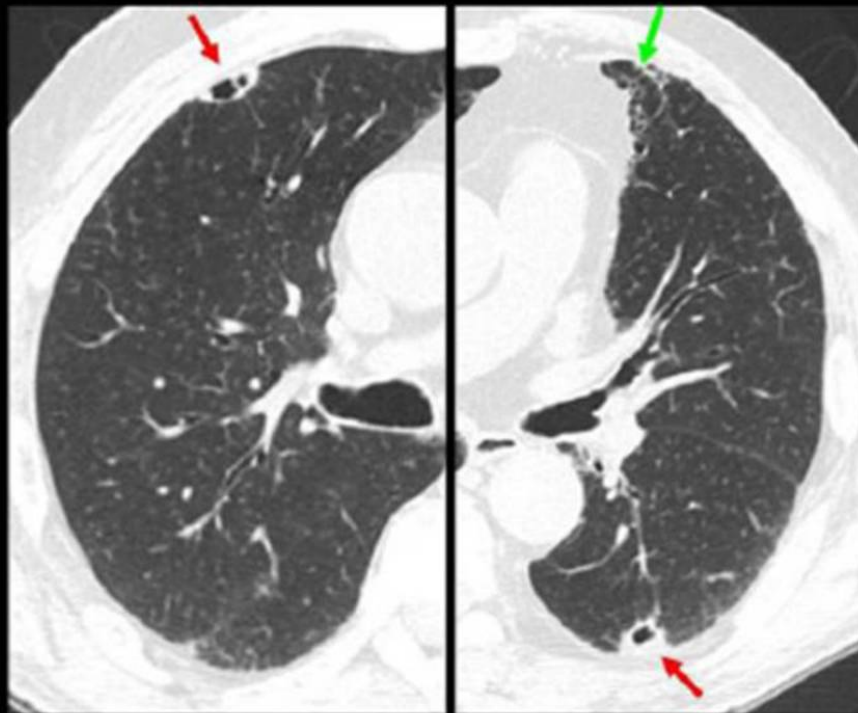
Rheumatoid arthritis. HRCT shows bilateral well-defined cavitated nodules (→). There is also intra and interlobular septal thickening and honeycombing in the anterior subpleural region of the left upper lobe, corresponding to fibrosis (→).
